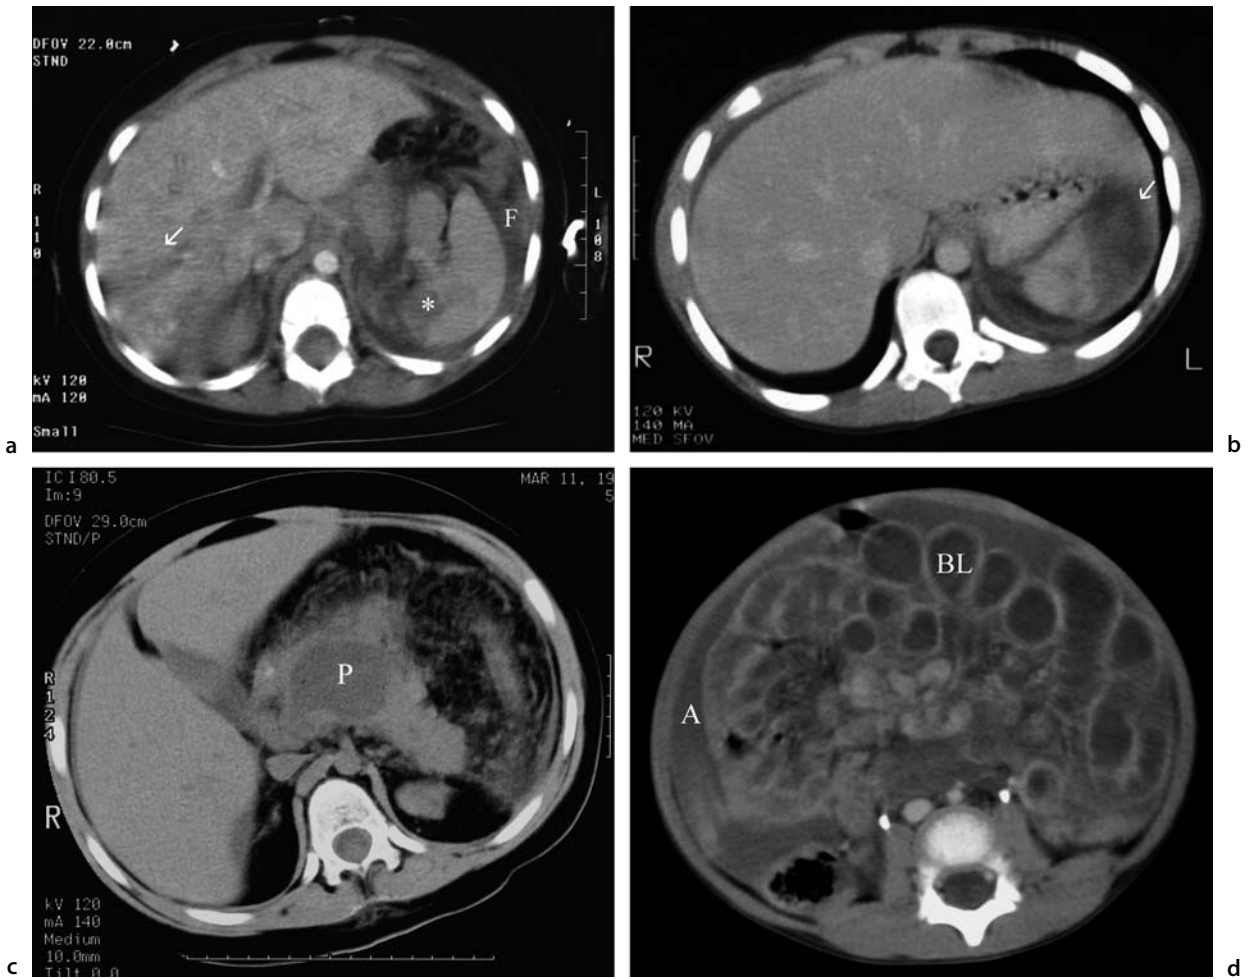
CT trauma of the abdomen
